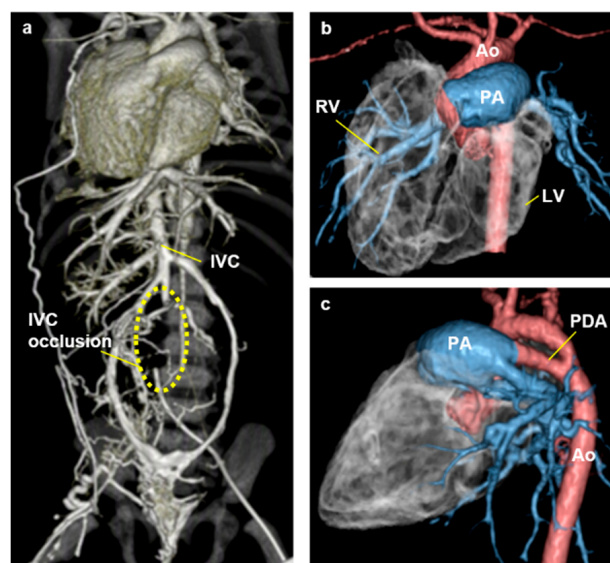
Contrast-enhanced computed tomography. (a) Dextroversion of the heart and inferior vena cava occlusion. (b) Frontal view shows right ventricular enlargement. (c) Lateral view shows patent ductus arteriosus, Krichenco type C. Ao, aorta; IVC, inferior vena cava; LV, left ventricle; RV, right ventricle; PA, pulmonary artery; PDA, patent ductus arteriosus.
